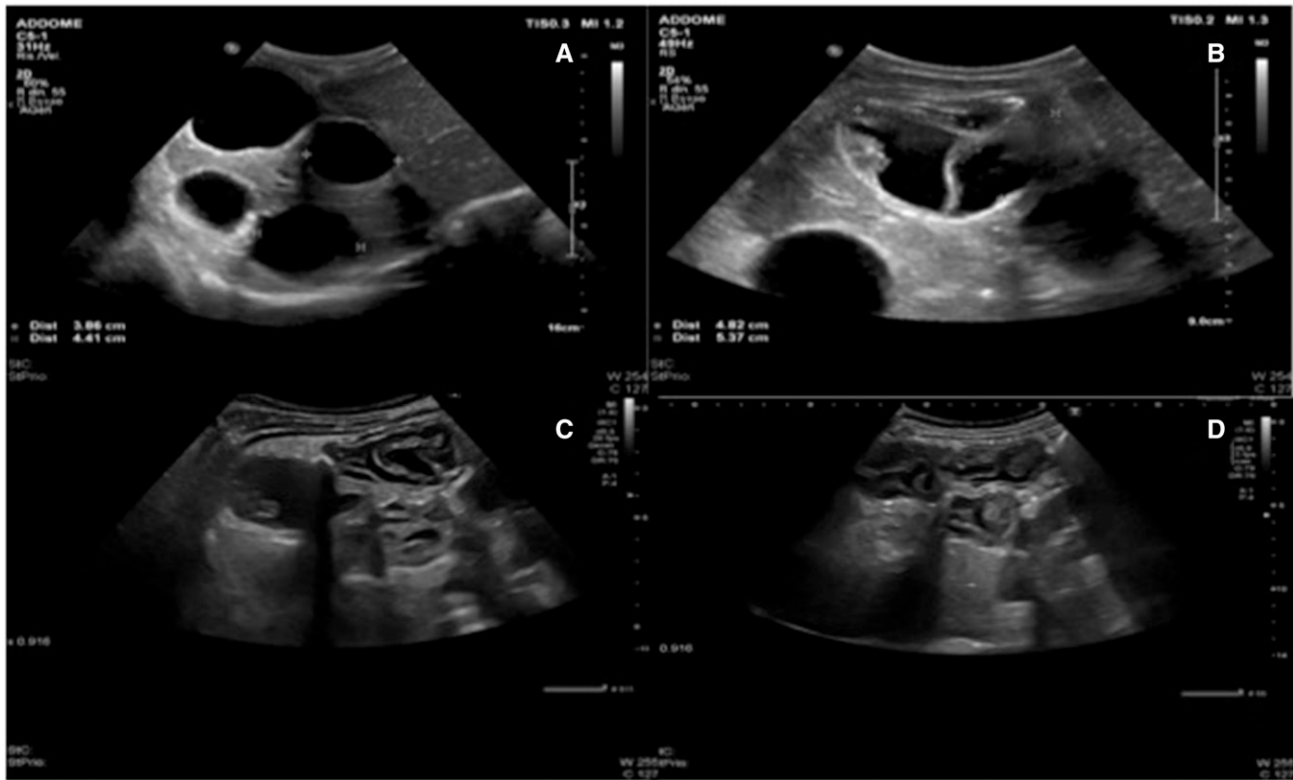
Abdominal ultrasound appearance of cysts. (A) Appearance of cysts at the diagnosis; (B) Detained appearance of the two treated cysts. The remaining findings were unchanged; (C) Involution of all eight hepatic hydatid cyst; (D) All cysts appeared inactive with a pseudotumor aspect.
